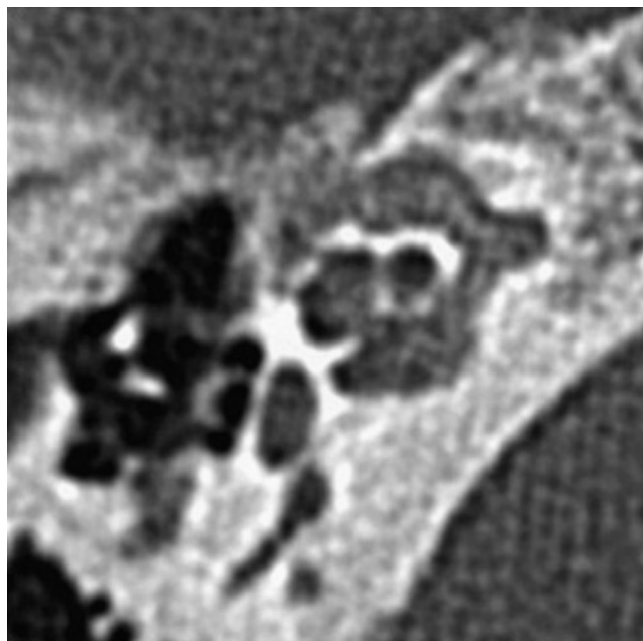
Pre-operative CT finding (right ear) of case 2.
